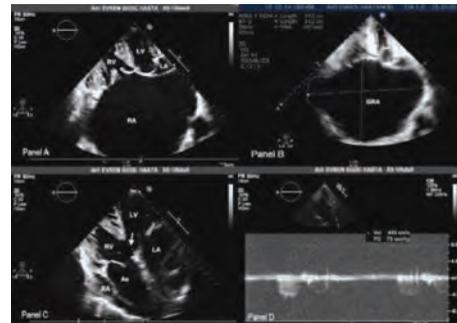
Transthoracic echocardiography of a patient with unrepaired ToF. Panel A: Apical four-chamber view showing a gigantic RA. Note that the left atrium was completely obscured by the GRA by mass effect which gave false impression as a three chambered heart. Panel B: The dimension of RA was measured as 19.3x14.2 cm and the planimetric area was 187 cm<sup>2</sup>. Panel C: Modified apical five-chamber view showing overriding aorta and a 2.5 cm VSD. Note that the RV is hypertrophied. Panel D: CW Doppler interrogation at RVOT revealed a gradient of 79 mmHg. CW: continuous wave, GRA: giant right atrium, LA: left atrium, RA: right atrium, RV: right ventricle, RVOT: right ventricular outflow tract, ToF: tetralogy of Fallot, VSD: ventricular septal defect.
